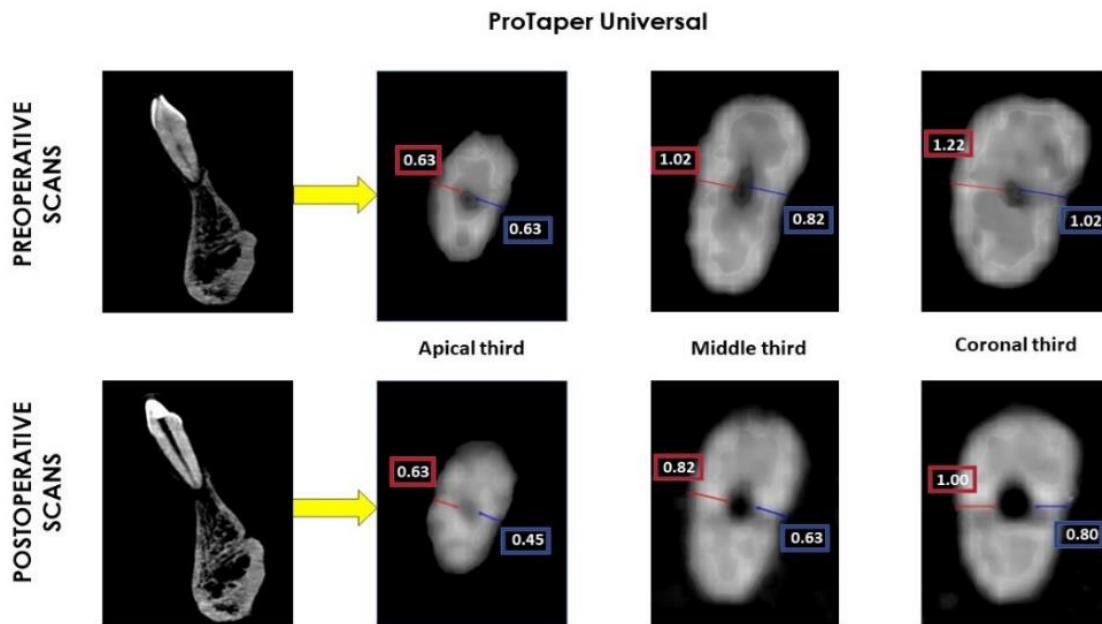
CBCT assessment of the remaining root dentin thickness in the danger zone of lower incisors after shaping with ProTaper Universal
